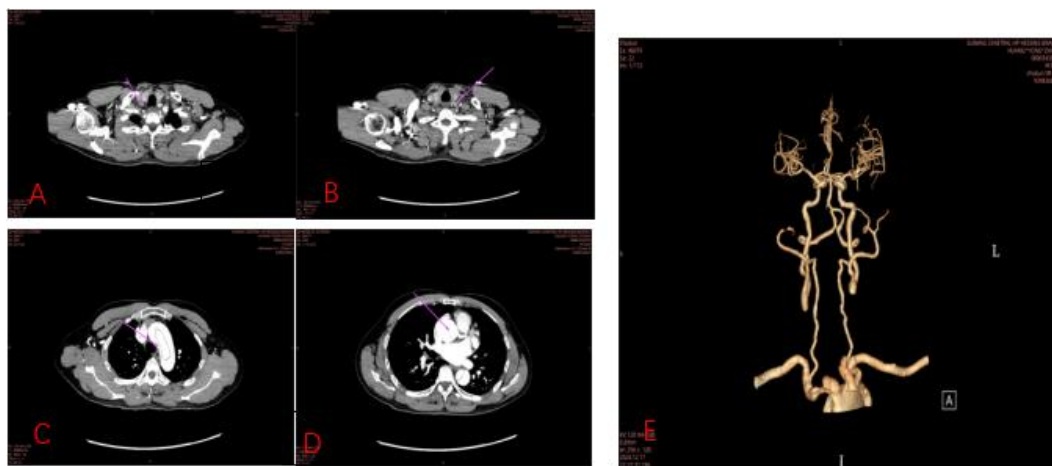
Preoperative Whole-Artery CT Images (A: Occlusion of the right common carotid artery; B: Occlusion of the left carotid artery; C: Intimal tear shadow of the aortic arch; D: Intimal tear shadow of the ascending aortic root dissection; E: Disappearance of blood flow in bilateral common carotid arteries with partial absence of the Willis Circle)
